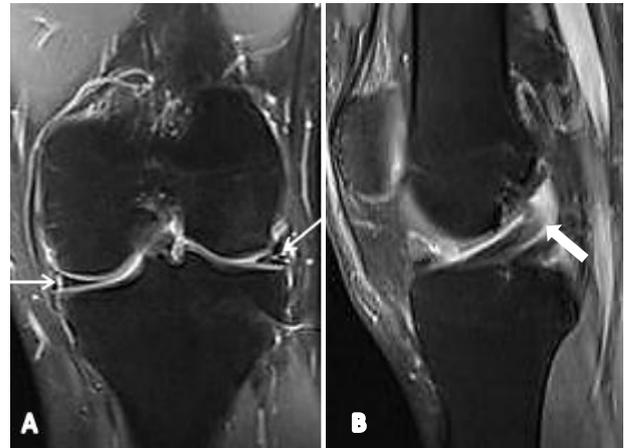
Associated ACL tear with meniscal injury in a 30-year-old male. (A) Coronal T2-weighted FSE fat-suppressed image shows medial and lateral meniscal tears (arrows). (B) Sagittal T2-weighted FSE fat-suppressed image shows associated complete tear of anterior cruciate ligament (thick arrow) in the same patient.
